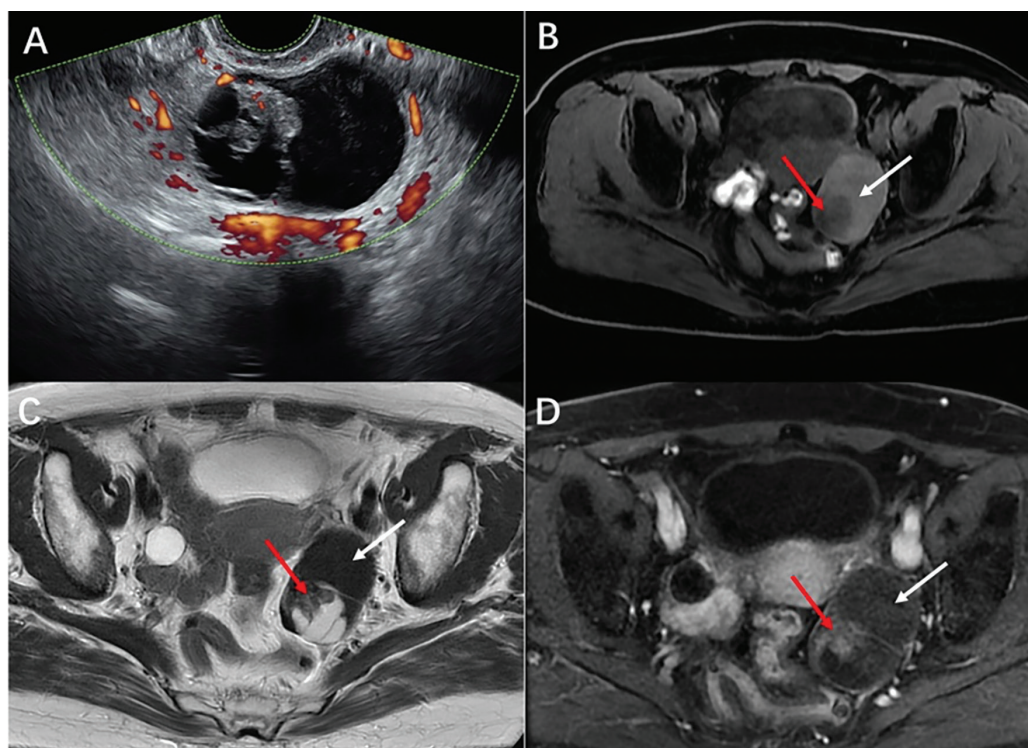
Pelvic ultrasound reveals a cystic-solid mass in the left adnexal region; pelvic magnetic resonance imaging demonstrates a heterogeneous mass in the same region with enhancement of the solid components
